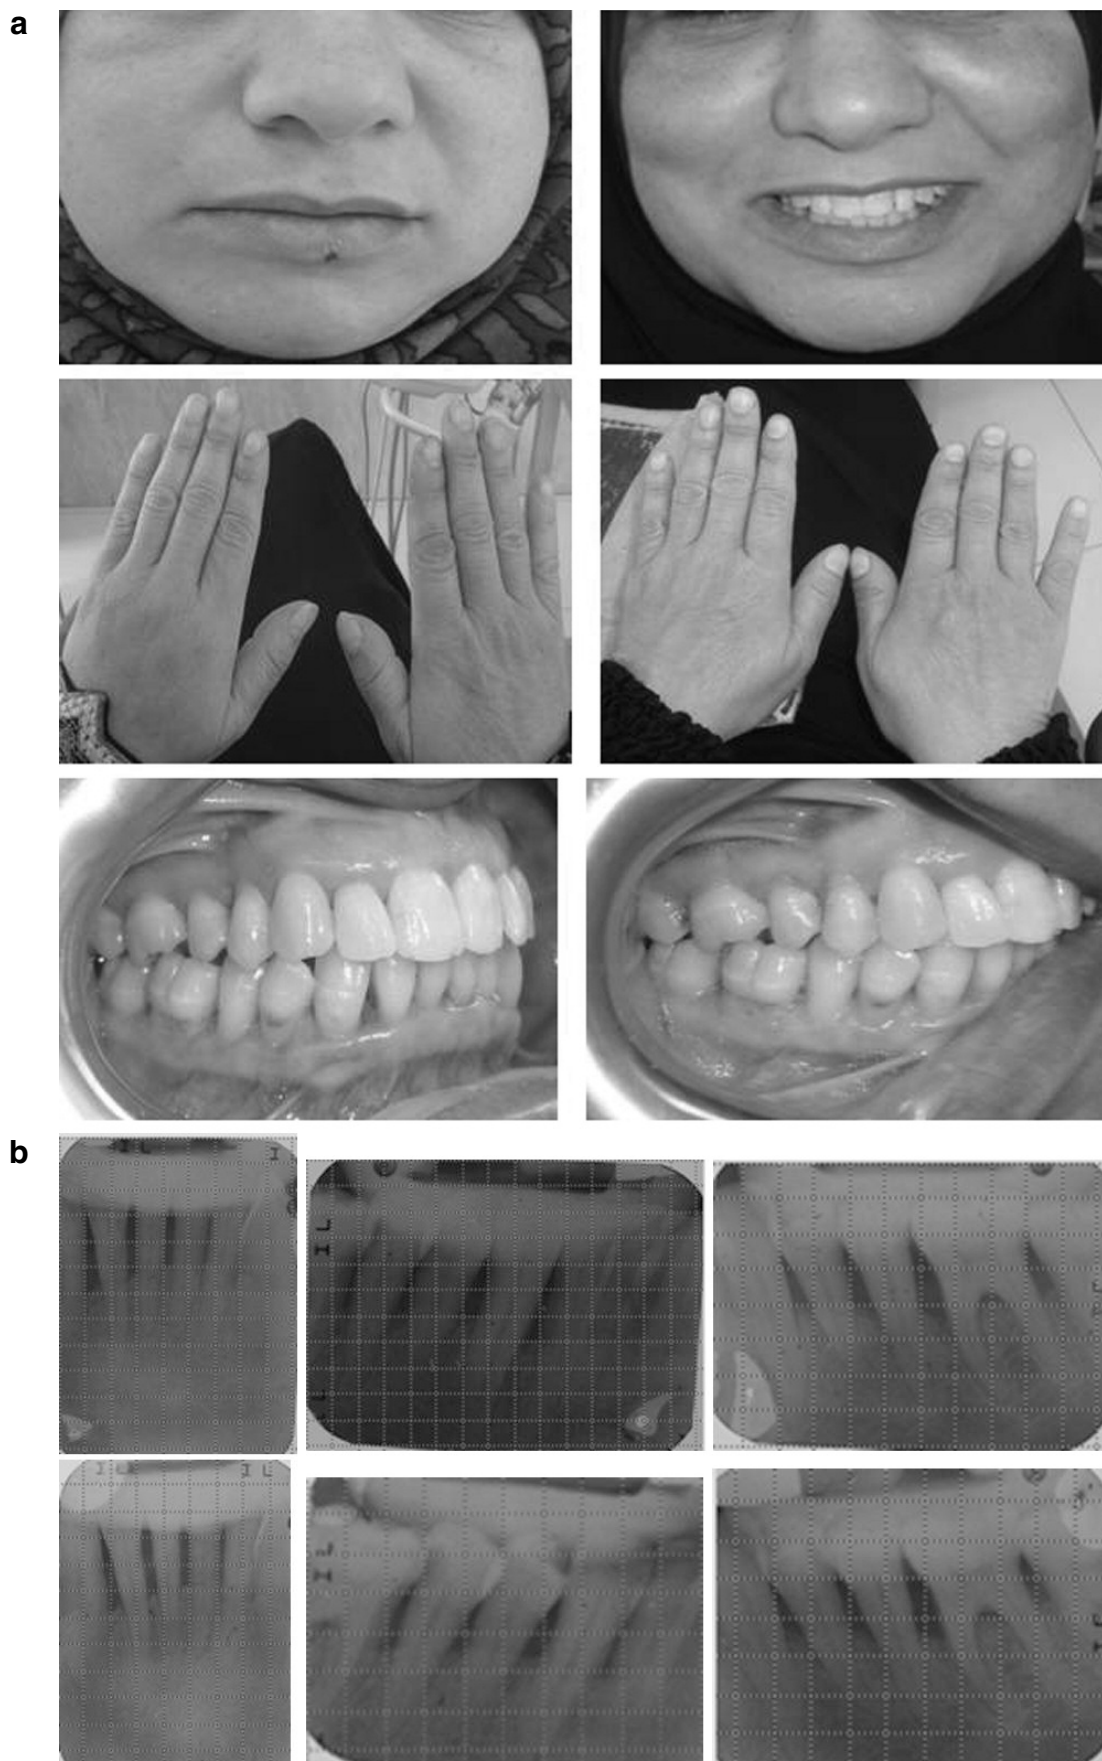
a, b - a) Pre and post-operative clinical; b) pre and post radiographic results.
